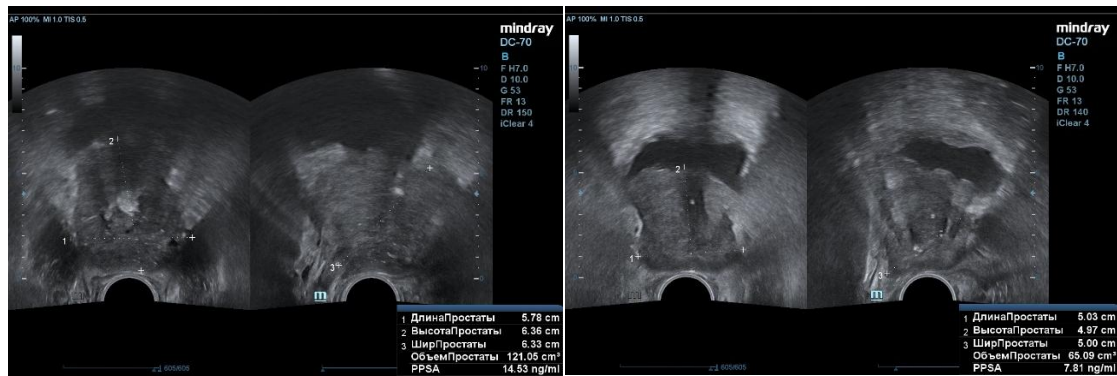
Prostate cancer (PCa). Transrectal ultrasound (TRUS) in grayscale mode.
